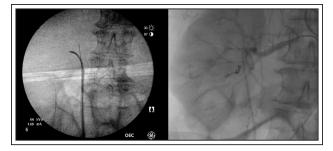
Left. The location of the pseudoaneurysm seen fluroscopically. Right. After localizing the vessel's location using a combination of ureteroscopy and CT angiograpahy, a coil was placed in the midpole segmental artery.
